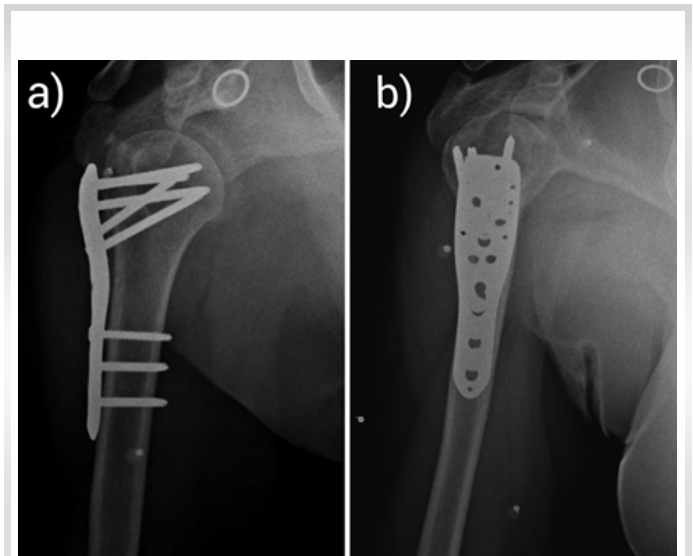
Two years follow-up plain radiographs anteroposterior (a) and lateral (b) views showing anatomical reduction of both the tuberosities with complete radiological healing.
